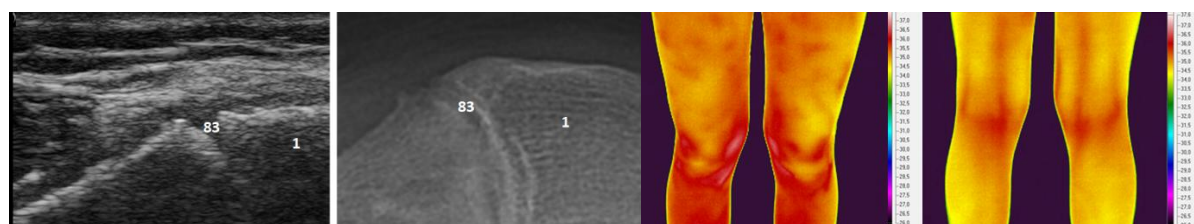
sono, Fig.11b.radiograph, Fig.11c.TMV AP, Fig.11d.TMV PA. Sono, X-ray: normal findings of growth plates. TMV: increased thermal activity in the area of growth plates of medial and lateral femoral condyles and tibiae bilaterally. 1. condylus medialis femoris, 83. growth plate.
